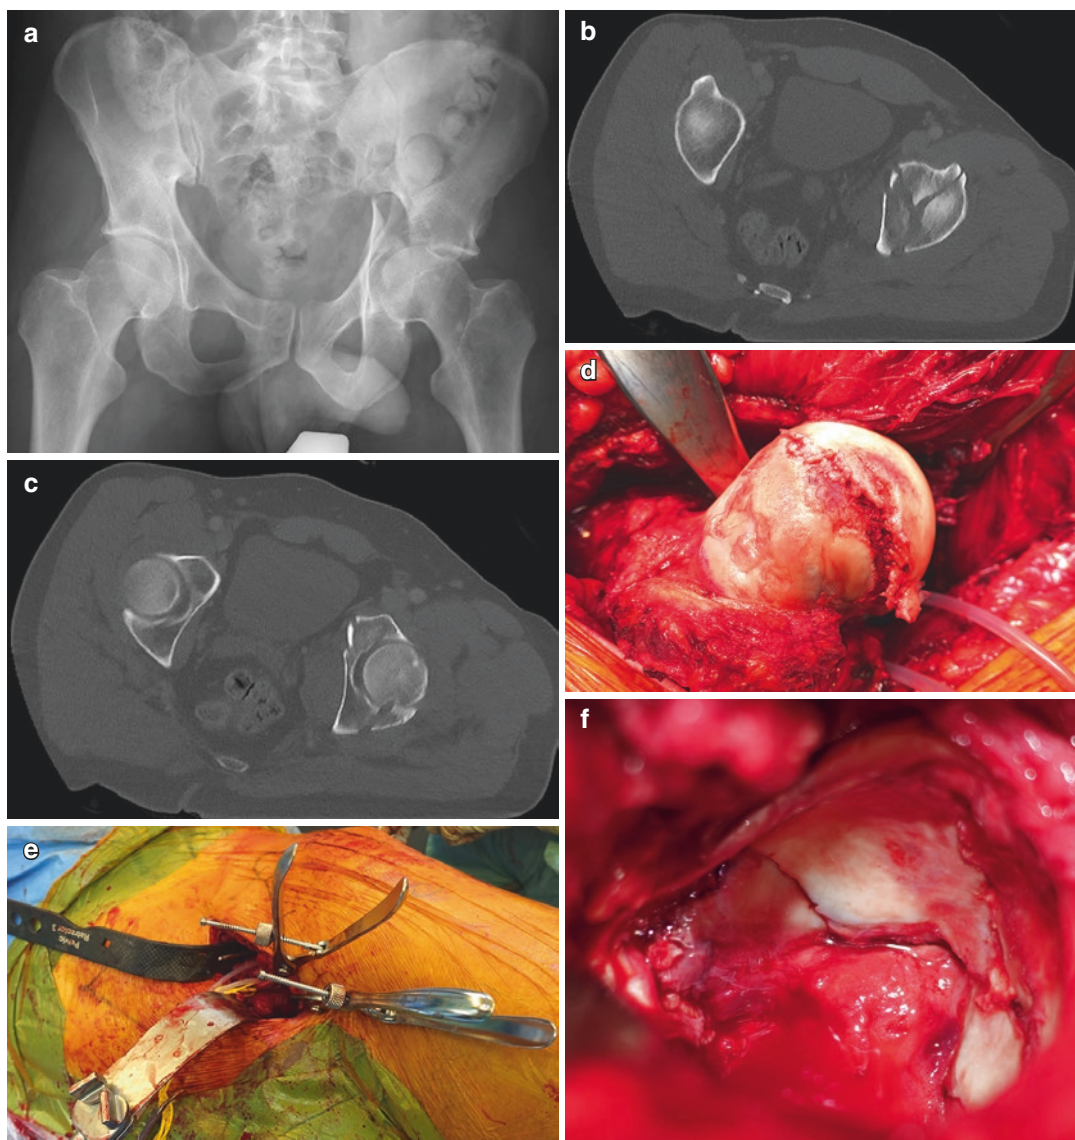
46 year old man with transtectal T-shaped fracture and a femoral head impaction on the left side after ski accident. AP pelvis (a) and axial CT cuts on the dome level (b) and distally with the displacement in the posterior column and impaction of the femoral head (c). Intraoperative views on the femoral head impaction during surgical hip dislocation (d), the Pararectus approach
